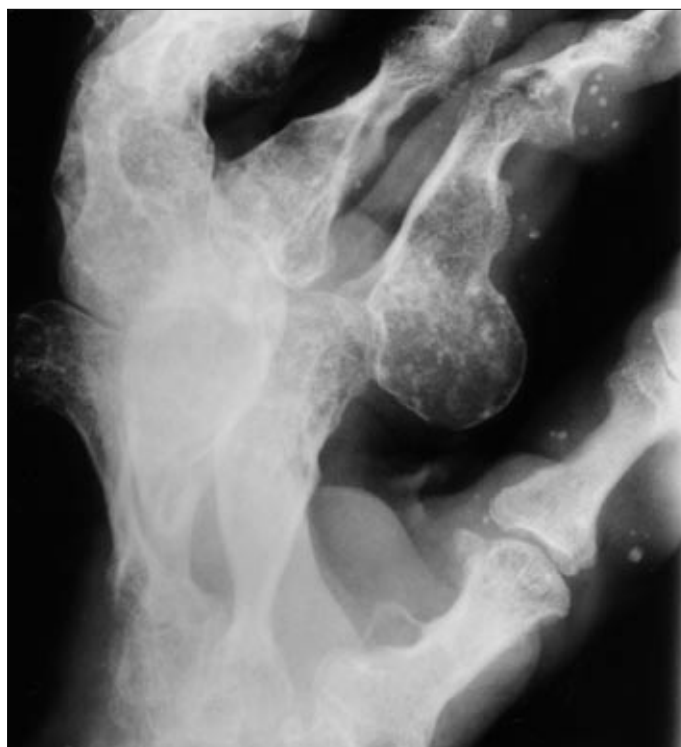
Maffucci's syndrome. Radiograph of the hand shows enchondromas in every bone and soft tissue masses that contain phleboliths. (Courtesy of Guerdon D. Greenway, MD.)
